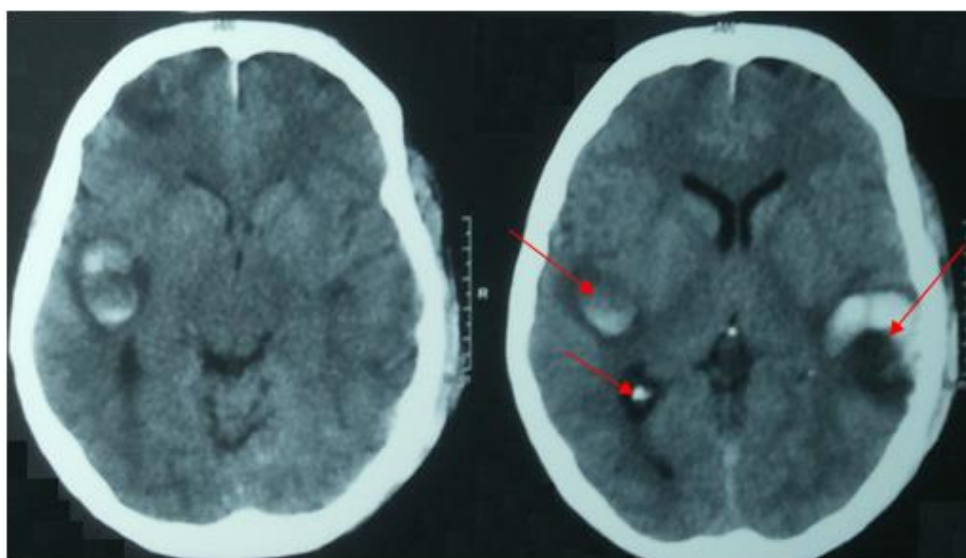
A male patient 34 years old presented with left and right temporo-parietal brain contusion. CT brain revealed bilateral brain hemorrhagic contusion left more than right with balanced midline. There is a small left subgaleal hematoma denoting the right lesion is countercoup brain trauma. The patient treated conservatively. Grade II : Modified Marshall classification (Less severe).
